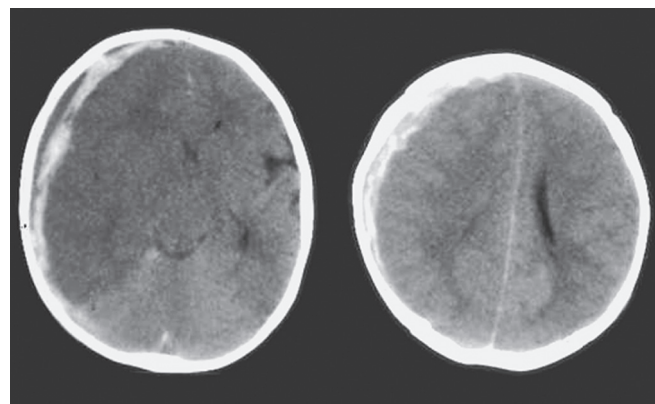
CT scan showing birth-related high-density hemorrhage along the tentorium and falx in a neonate.
